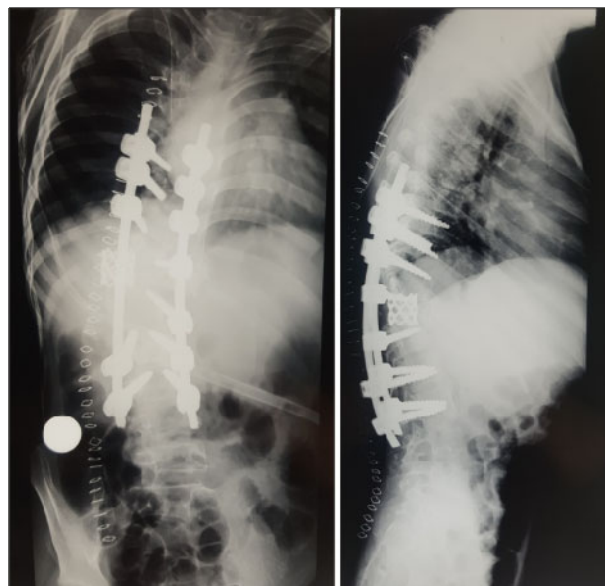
Postoperative day 2 radiograph anteroposterior and lateral view of spine depicting correction of kyphoscoliosis with cage, bone graft, pedicular screws and titanium rods in place.
